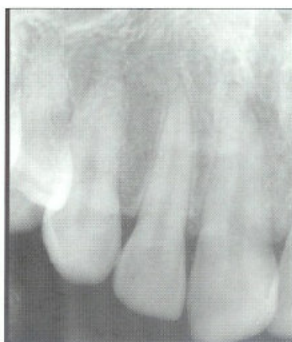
Six-month postoperative radiograph, maxillary anterior right side
